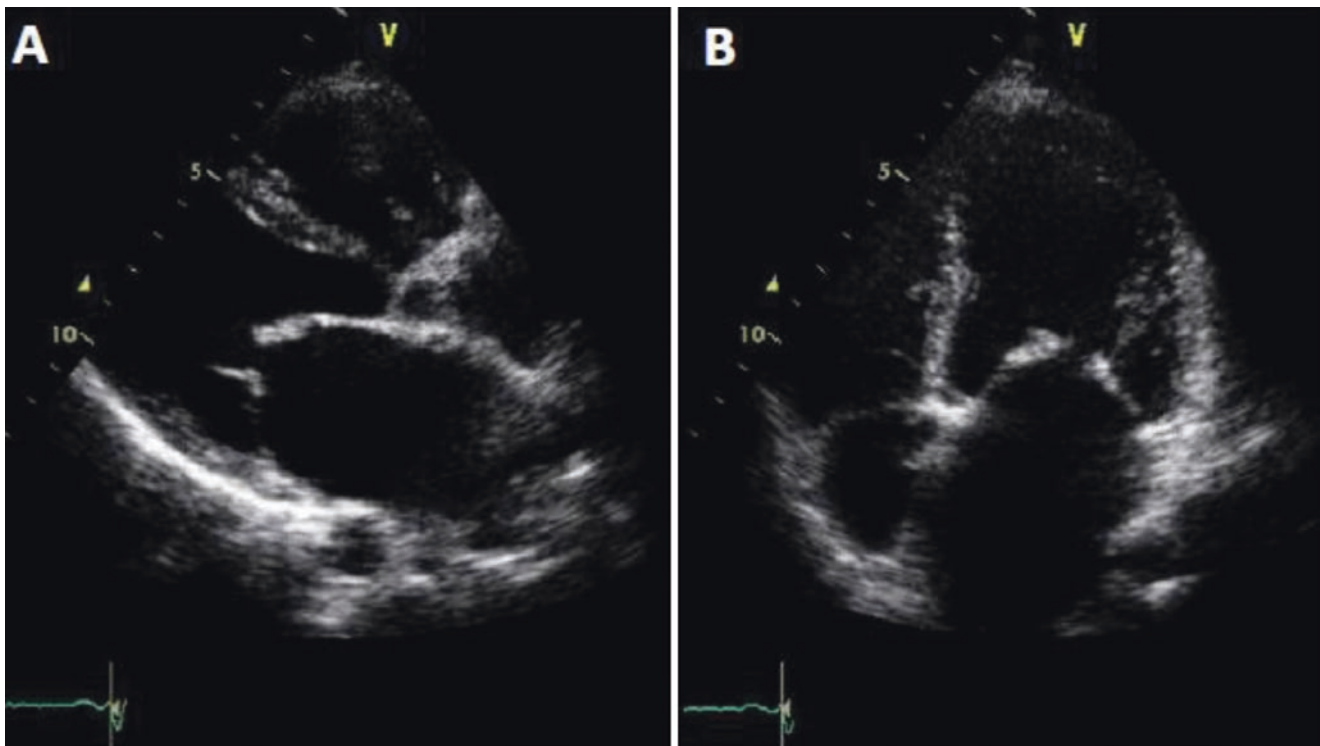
Parasternal long axis (a) and 4-chamber (b) views showing a rheumatic mitral valve—note the typical “hockey stick” appearance of the anterior leaflet
